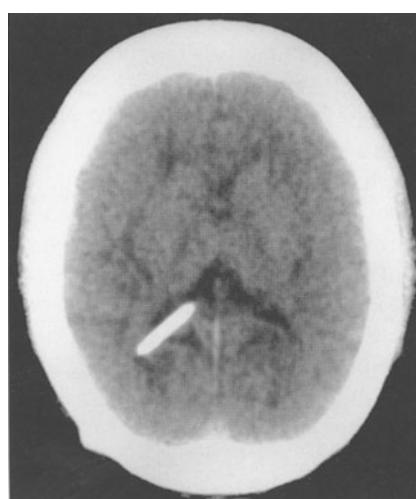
Axial CT scan in a 28-year-old patient with shunted hydrocephalus. The ventricles are small, the skull is thickened
